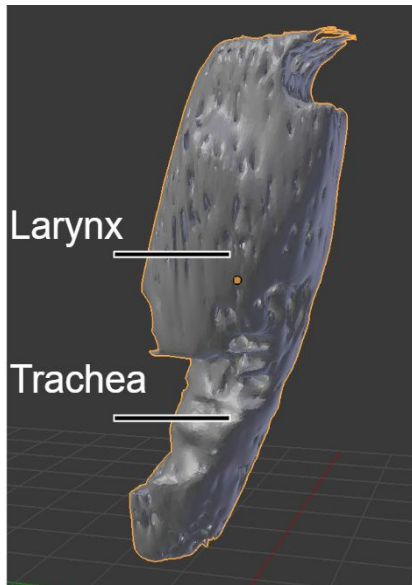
The upper respiratory tract upon the initial importation of the CT into Blender.
